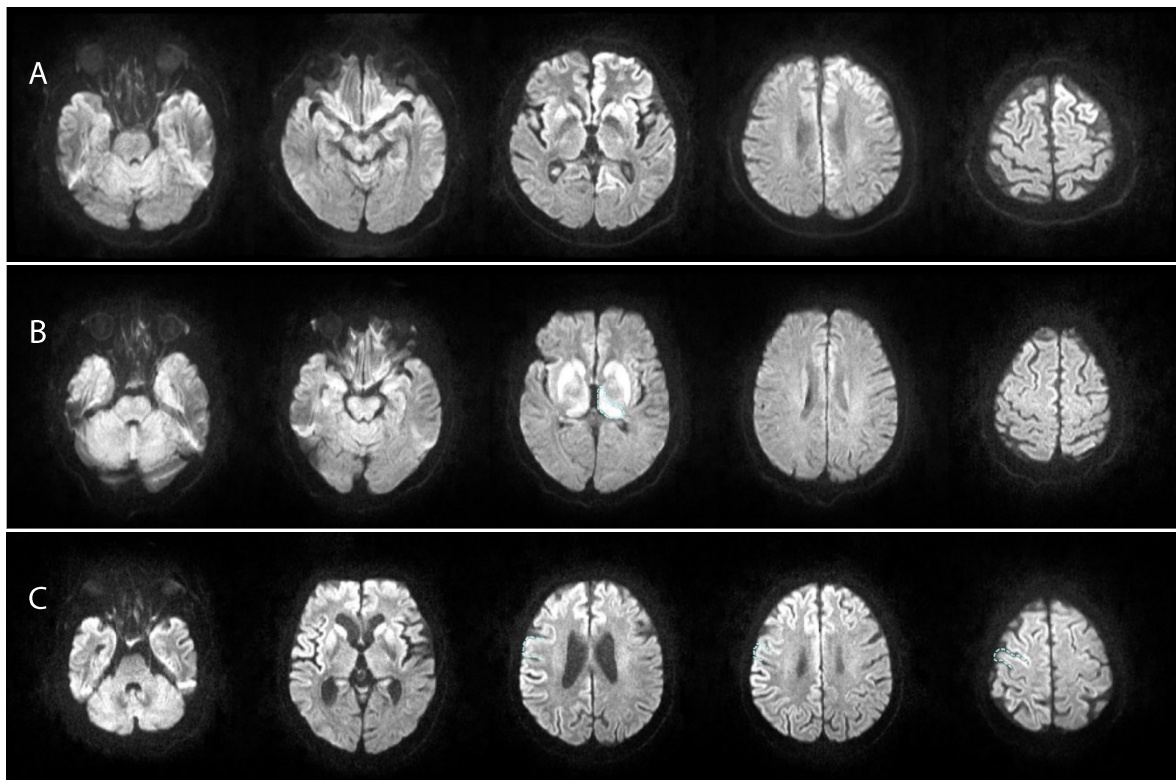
Lesion patterns of selected sJCD patients. A Typical distribution of sJCD lesions on DWI. One may notice the symmetric involvement of basal ganglia, temporal poles, frontal cortex and insular region. The motor cortex and cerebellum is spared. B Hockey stick sign in sJCD. The thalamic region is affected (highlighted area). C Involvement of motor cortex (right). High signal abnormalities of this patient's right motor cortex (highlighted area) was found in compliance to its left sided hemiparesis.
